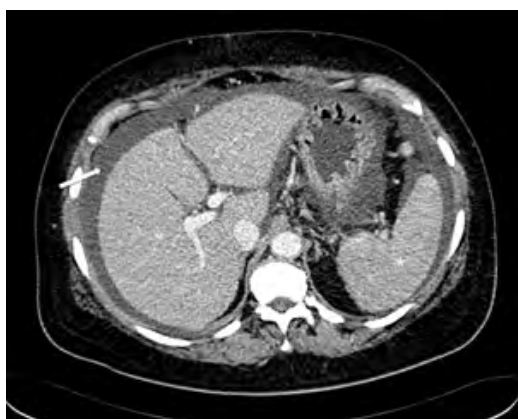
Computed tomography (CT) of the abdomen, case 1. CT of the abdomen (venous phase) showing the presence of ascites (arrow) and modest splenomegaly (asterisk)
